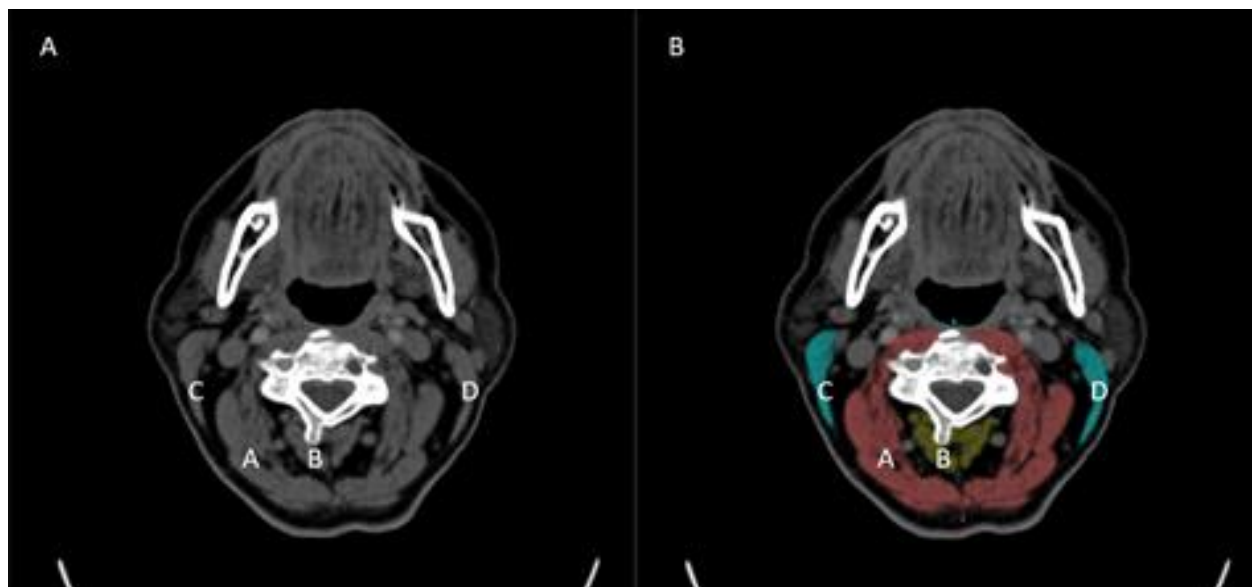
Example of the used delineation software. Image A: Exported CTA slice at the C3 level without delineation. Image B: Exported CTA slice at C3 level with delineation of all the muscles. Muscle A (red): Paravertebral muscle, muscle B (yellow): spinal muscles, muscle C (blue): right sternocleidomastoid muscle, muscle D (blue): left sternocleidomastoid muscle.
